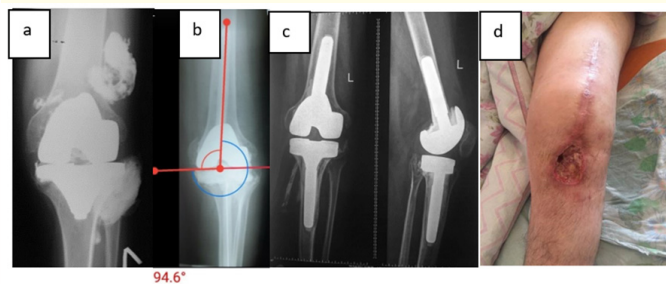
X-rays at T₀, T₃ and T_{LFU}, photo of the knee at TLFU for clinical case 1.
